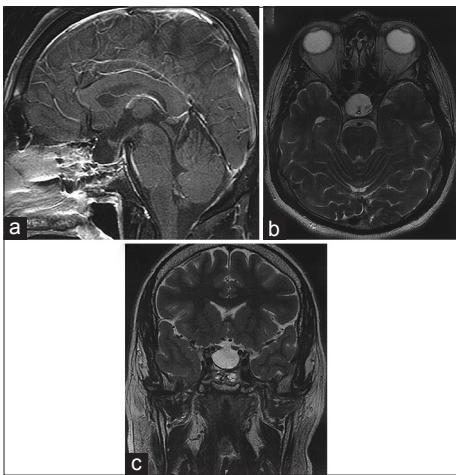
Postoperative contrasted sagittal T1 (a), axial (b) and coronal (c) T2 MR images demonstrating gross total resection of the pituitary adenoma
